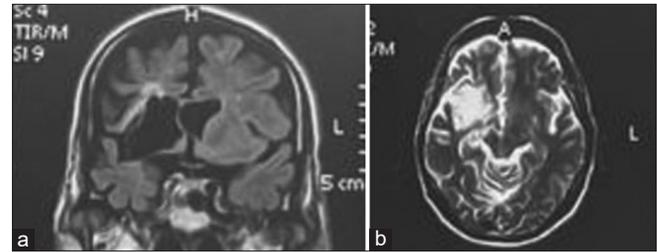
(a) Preoperative T1-weighted magnetic resonance imaging (MRI) image (coronal view) showing periventricular old ischemia alongside cerebrospinal fluid (CSF)-filled cleft in the right-sided hemisphere. (b) Preoperative T2-weighted MRI image (axial view) revealing periventricular longstanding ischemic changes and unilateral CSF-filled cleft in the right hemisphere extending from the frontal horn of the lateral ventricle to the Sylvian fissure.
